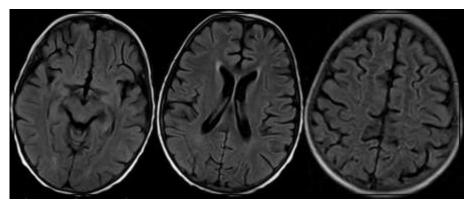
Control MRI achieved after 19 days from the event, FLAIR slices are showing normal findings on which vasogeniced emasites have all dissappeared
